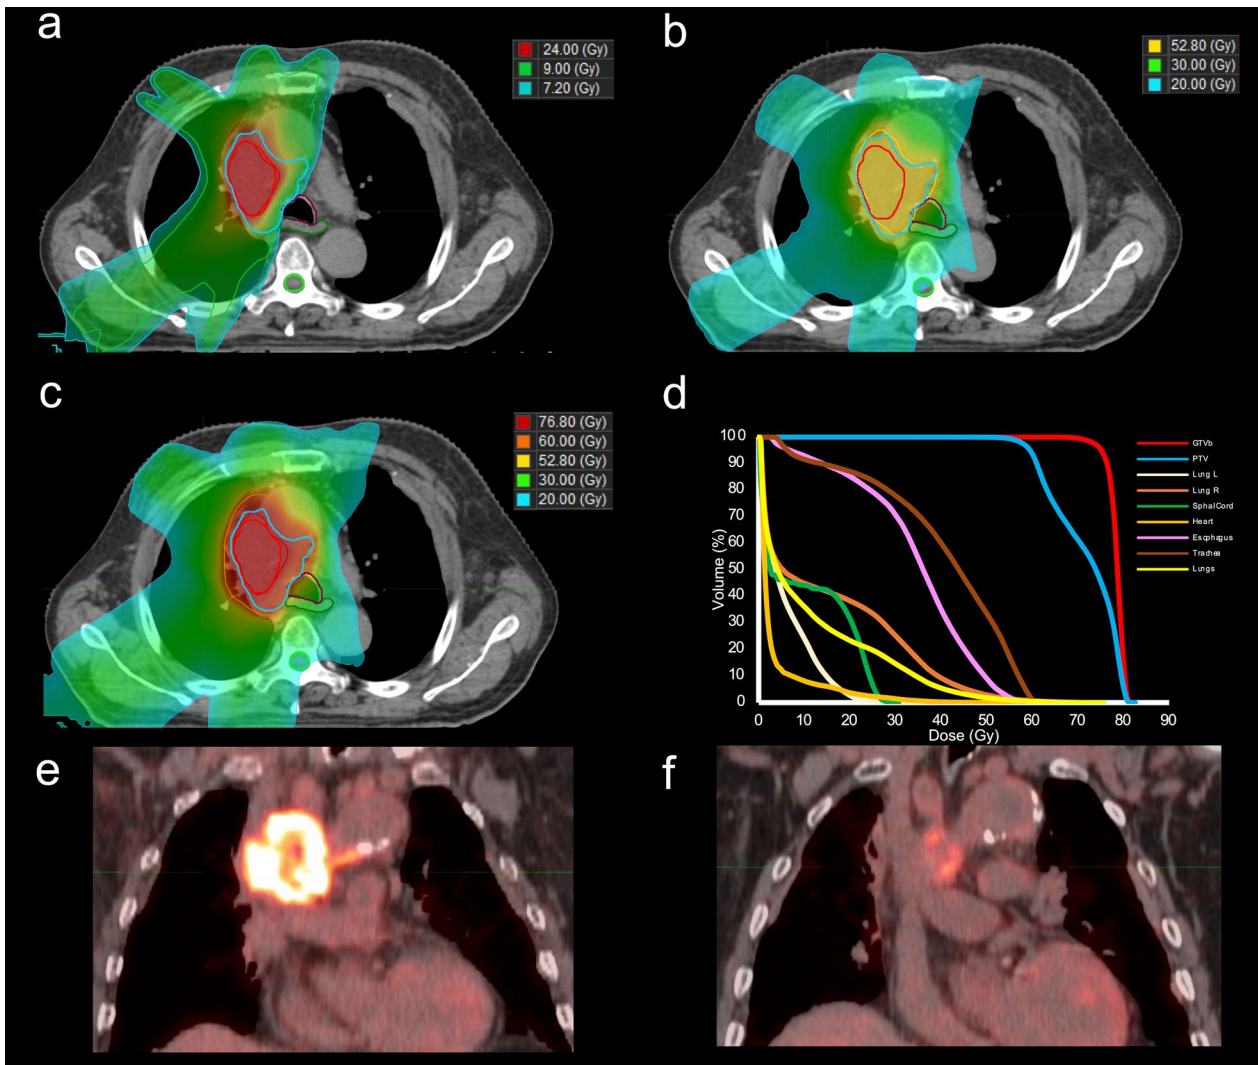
A typical patient with cT4N3M0 NSCLC. The primary site and ipsilateral mediastinal metastatic lymph nodes were treated by P-SABR, while the supraclavicular lymph nodes were treated by CFRT (60 Gy in 25 fractions) concurrently. The greatest tumor diameter treated with P-SABR was 9.1 cm. (a) Contours of the GTV (blue line) and the gross tumor boost volume (GTVb) (red line). In the partial SABR plan, a dose of 24 Gy in 3 fractions was delivered to the GTVb, while the prescription dose for the GTV was 7.2 Gy in three fractions. The maximum dose to the spinal cord and esophagus was 3 Gy per fraction. (b) In the subsequent conventional radiotherapy plan for P-SABR, a dose of 52.8 Gy in 22 fractions was delivered to the GTV. (c) In total, the cumulative doses of GTV and GTVb were 60 and 76.8 Gy, respectively. (d) Dose and volume histogram (DVH) of the synthetic P-SABR plans. (e) Patient's pretreatment PET/CT scan. (f) PET/CT scan performed 13 months after treatment, which showed partial response and relief of the superior vena cava compression.
